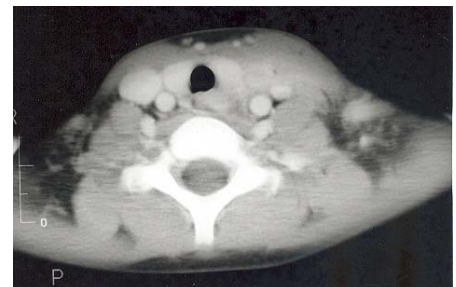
Contrast enhanced axial computed tomographic image scan shows increased enhancement and swelling of the left perithyroid soft tissue, together with loss of the normal high attenuation and ill definition of the adjacent left thyroid lobe.
